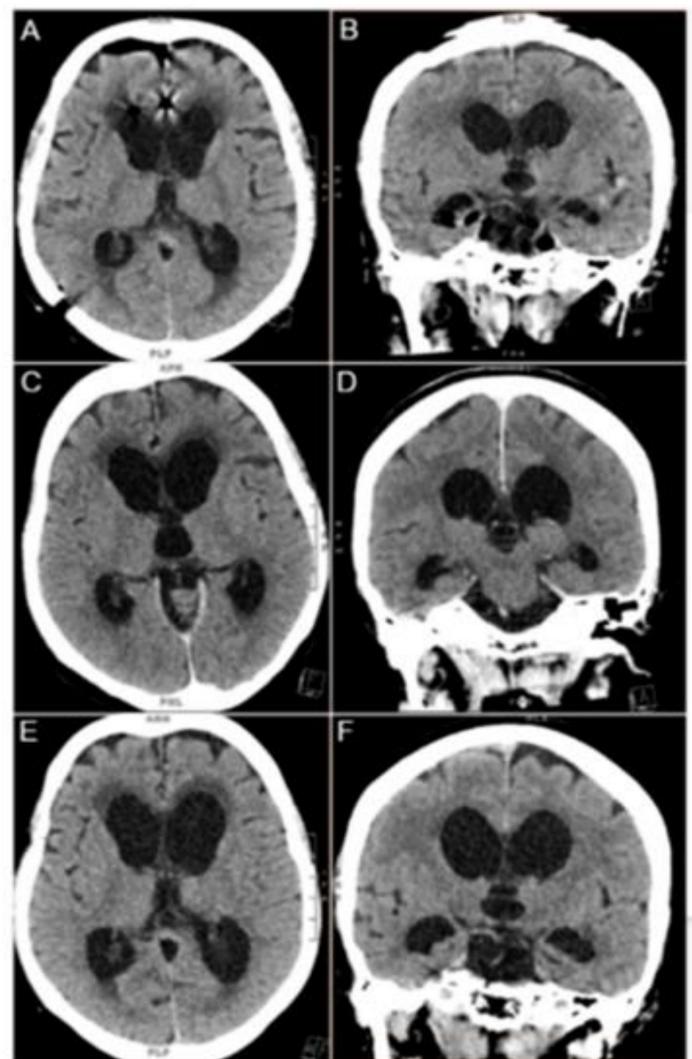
Postoperative computed tomography (CT) scans in the axial (A,C,E) and coronal (B,D,F) planes demonstrate marked progressing ventriculomegaly. Images A and B are from the immediate postoperative period (POD 0), images C and D are from POD 14, and images E and F are from POD 39. A parietal entry catheter can be seen in image A, with linear encephalomalacia noted along the course of the catheter. Periventricular hypodensity, potentially representing chronic small vessel disease or transependymal CSF flow was noted across all time periods. At maximum size, the third ventricle measured approximately 20 mm in transverse dimension.
